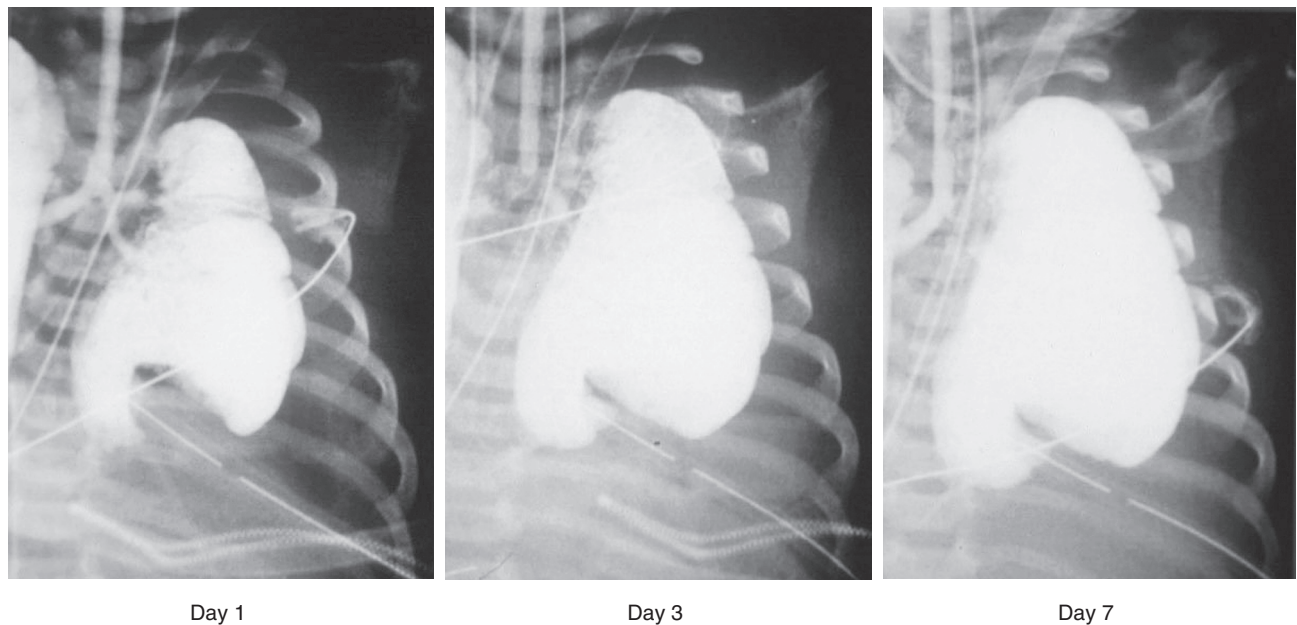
■ Plain chest radiographs from a neonate with congenital diaphragmatic hernia, showing the progress of the ipsilateral lung during intrapulmonary distention with a perfluorocarbon (radiopaque) for 7 days. Notice its obvious increase in size, which did not happen in the contralateral lung. (Reproduced with permission from Fauza DO, Hirschl RB, Wilson JM: Continuous intrapulmonary distention with perfluorocarbon accelerates lung growth in infants with congenital diaphragmatic hernia: initial experience. *J Pediatr Surg* 36:1237–1240, 2001.)
